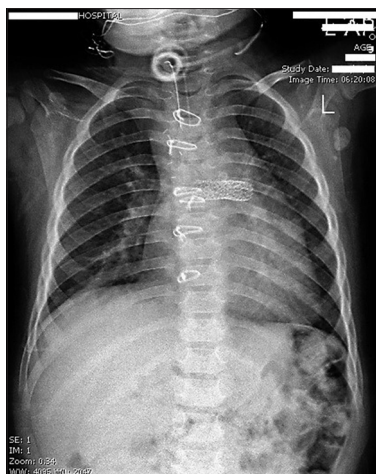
Chest X-Ray several months after Glenn shunt procedure with tracheostomy in place
